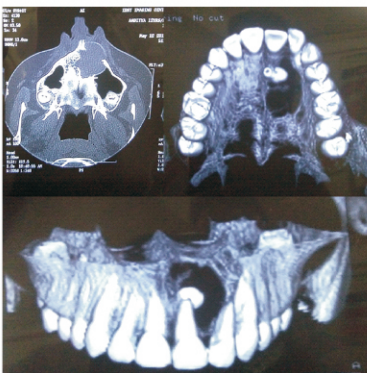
Radiographic presentation of the lesion
